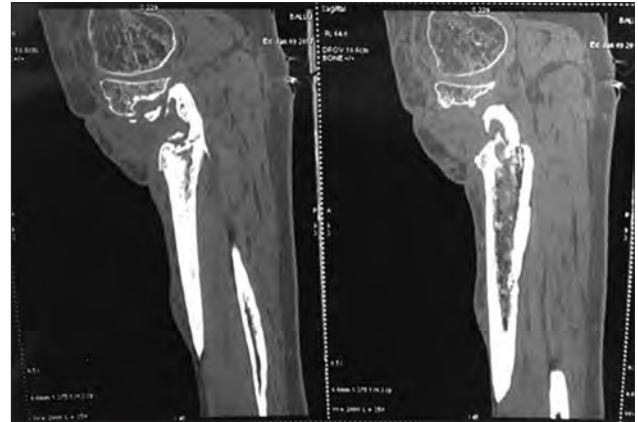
Pre-op Sagittal CT
